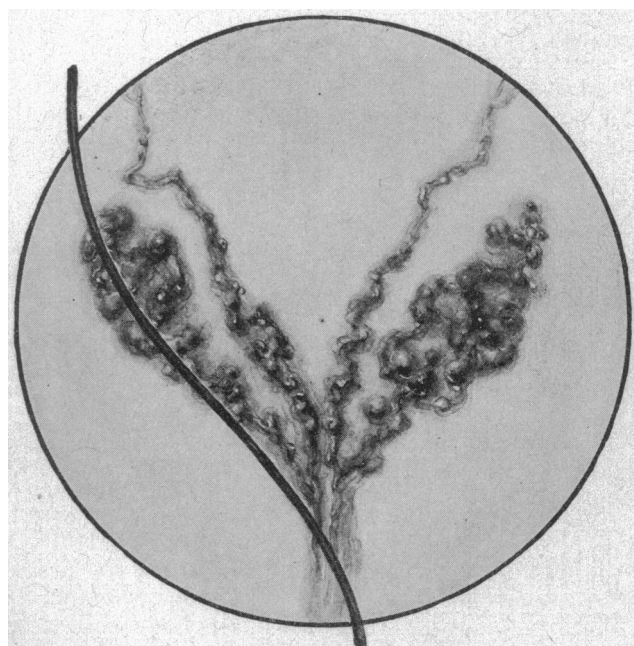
From plate made by Belfield showing relation of ureter to seminal vesicle. Vesicle filled with collargol solution. Roentgen-ray catheter in ureter.
